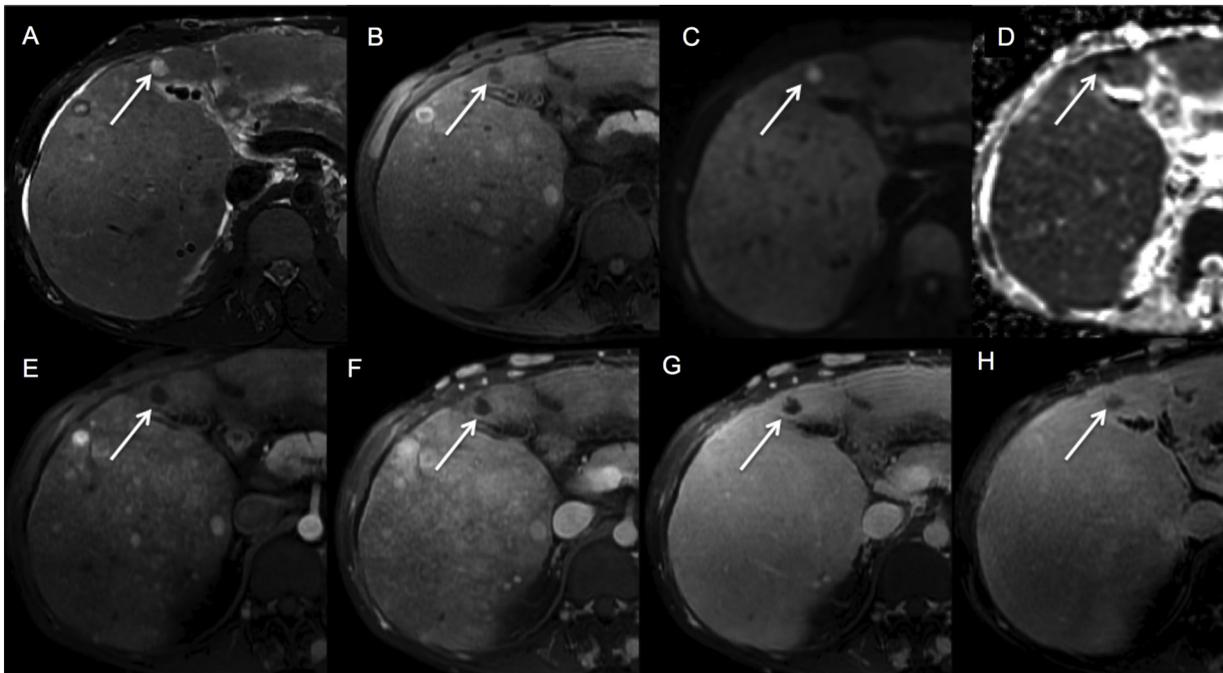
Necrotic regenerative nodule. MRI obtained after intravenous bolus injection of gadobenate dimeglumine show a necrotic regenerative nodule (white arrow) hyperintense on T2 (a), hypointense on T1 (b), hyperintense on DWI (c) with diffusion restriction on ADC map (d), constantly and strongly hypointense on all contrastographic phases (e–g) and hypointense on hepatobiliary phase (h).
